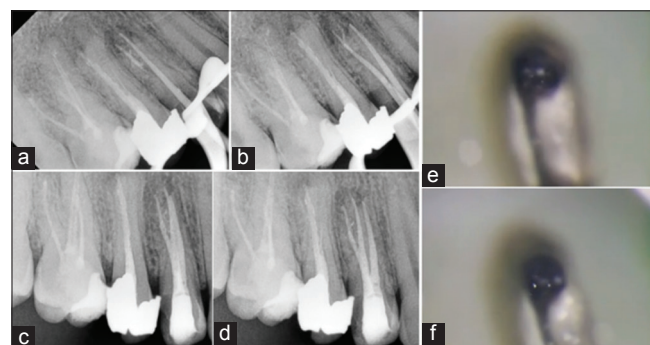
Maxillary right first premolar. (a and b) Periapical radiograph of match cone fit. (c and d) Final radiograph. (c) Straight periapical radiograph. (d) Mesial periapical radiograph. (e and f) Photograph of buccal orifice showing MB and DB canals
